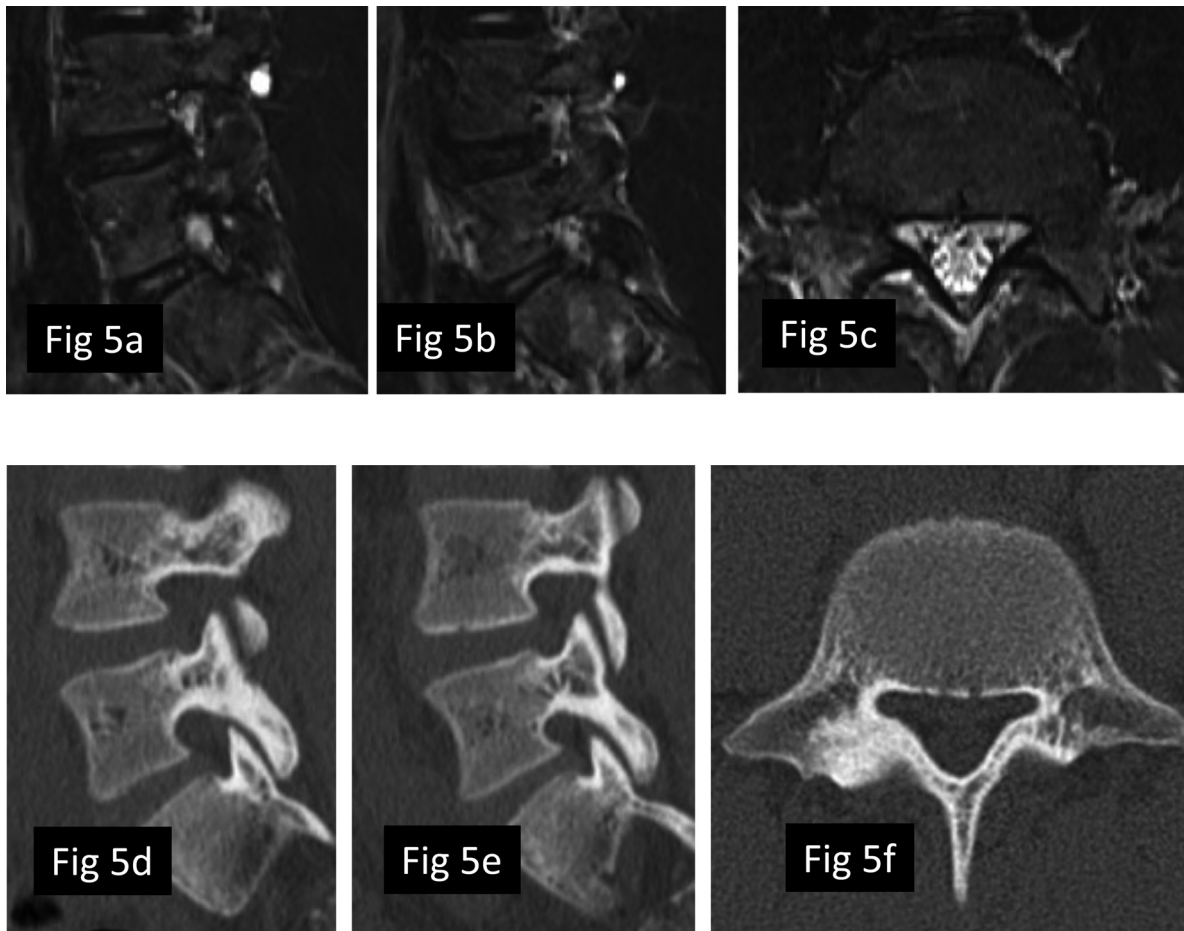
Case 2 after conservative therapy. a–c) Three months after the first visit to the hospital, MRI STIR was normal. d–f) CT indicated bony union had been achieved.
